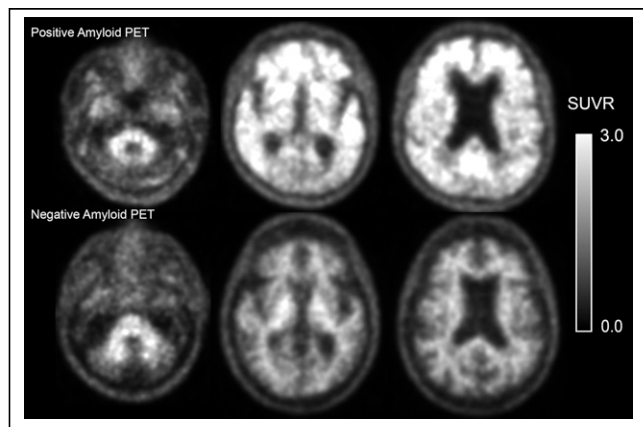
Amyloid PET. (Top row) Positive amyloid PET scan with loss of gray-white differentiation and areas of abnormally increased cortical uptake in multiple regions of cerebral hemispheres. This is compatible with presence of moderate to frequent amyloid- β neuritic plaques. (Bottom row) In contrast, negative amyloid PET scan has distinct gray-white contrast in all lobes, with distinctly visible branching white matter tracts. SUVR = SUV ratio.
